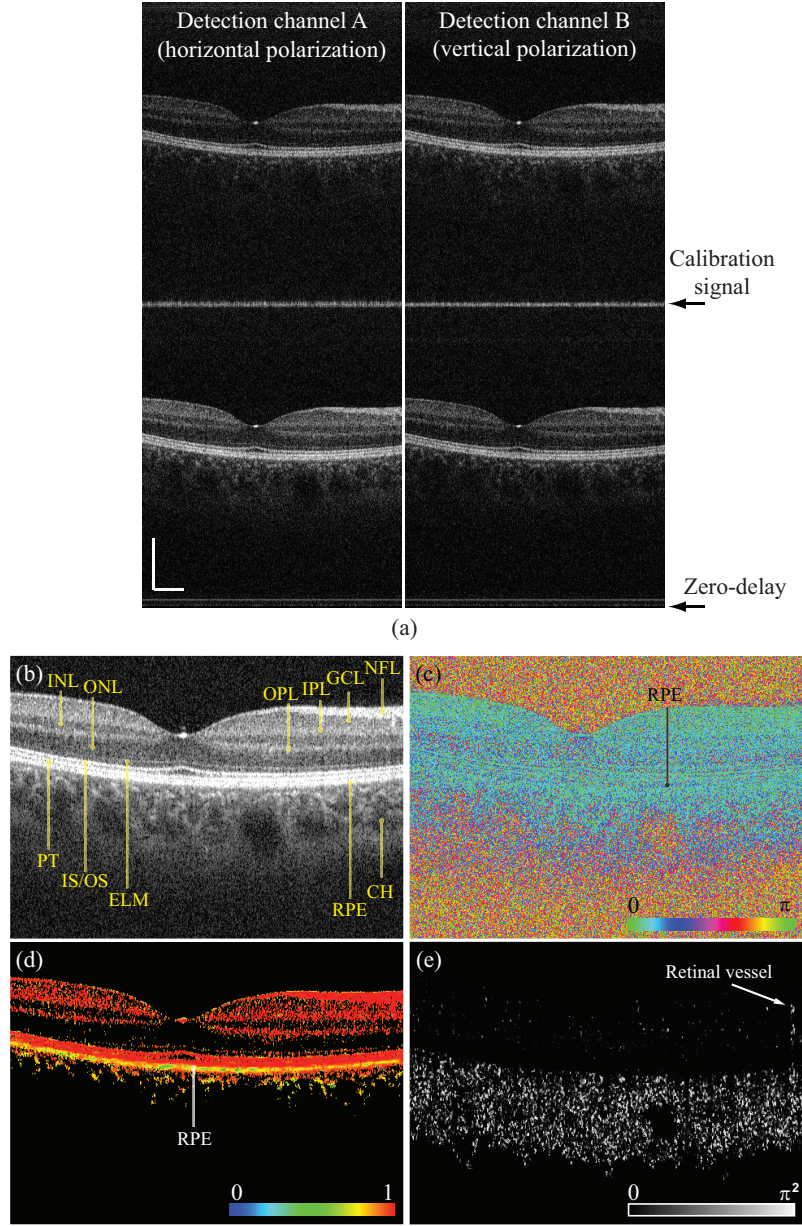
Jones matrix cross-sectional images of a normal macular. (a) Raw OCT intensity images detected by detection channels of A (horizontal polarization) and B (vertical polarization) of the PD detection unit. The lower and upper images correspond to the first and second polarization state, respectively. (b) Global-phase-corrected sensitivity-enhanced scattering OCT obtained by coherent composition. (c) A phase retardation image, (d) A DOPU image, (e) power-of-Doppler-phase-shift image (e). The scale bar represents  $500 \mu\text{m} \times 500 \mu\text{m}$ . (Source: Ju et al. *Advanced multi-contrast Jones matrix optical coherence tomography for Doppler and polarization sensitive imaging* [90])
